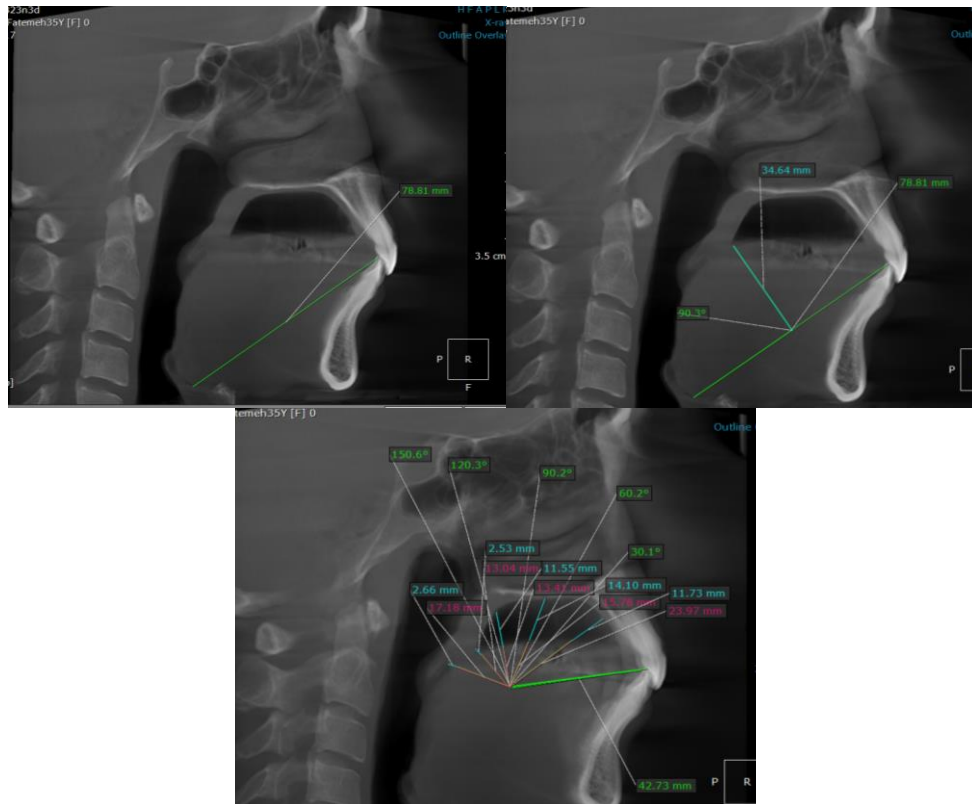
Tongue analyses; (a) TGL; (b) TGH; (c) Tongue posture on 3D view in X-ray and R modes
